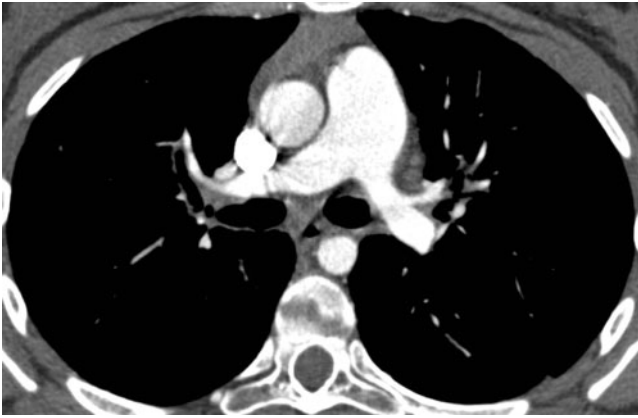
High-resolution CT image demonstrating the enlarged main pulmonary artery compatible with subsequently proven pulmonary arterial hypertension.
